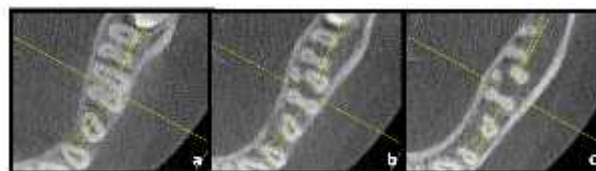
CBCT images at (a)coronal, (b)middle and (c) apical third of 36 respectively
